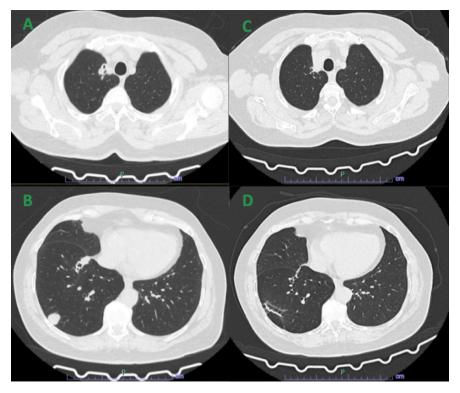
High-resolution chest computed tomography (CT) scan showing a reduction in the size of subpleural and parenchymal rheumatoid nodules, along with bronchiectasis, comparing the initial CT (images A and B) with the follow-up scan six months after initiation of upadactinib therapy (images C and D) in patient 2.
